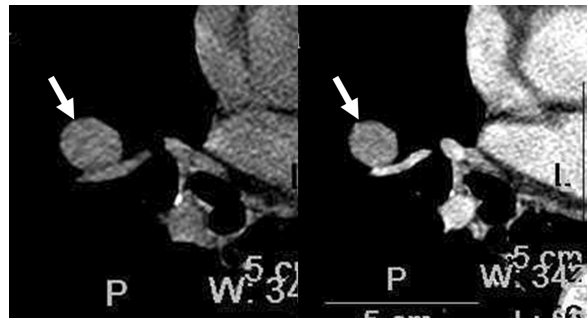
A 58-year-old man with typical carcinoid. Mediastinal window images of transverse CT scans before (left) and 60 s after (right) contrast medium injection show enhancing nodules (arrows; 37 HU on unenhanced scan and 76 HU on enhanced scan) in the right middle lobe.
